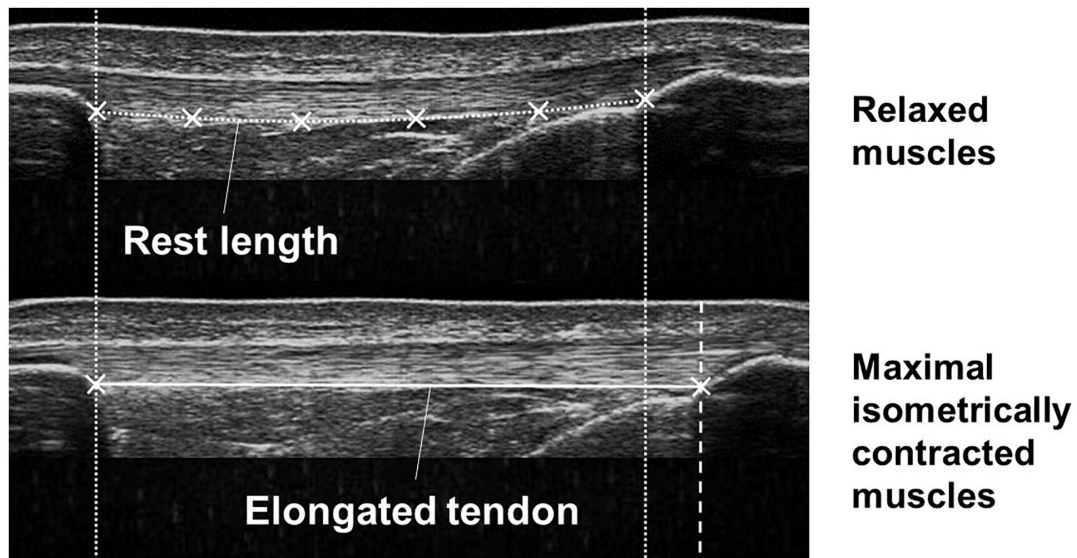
Ultrasound images demonstrating the tendon in the relaxed (upper image) and maximal isometrically contracted state (lower image) of the muscles. Tendon rest length and tendon elongation were measured defining reference points at the patellar apex and the tibial tuberosity and the deep boundary of the tendon.
